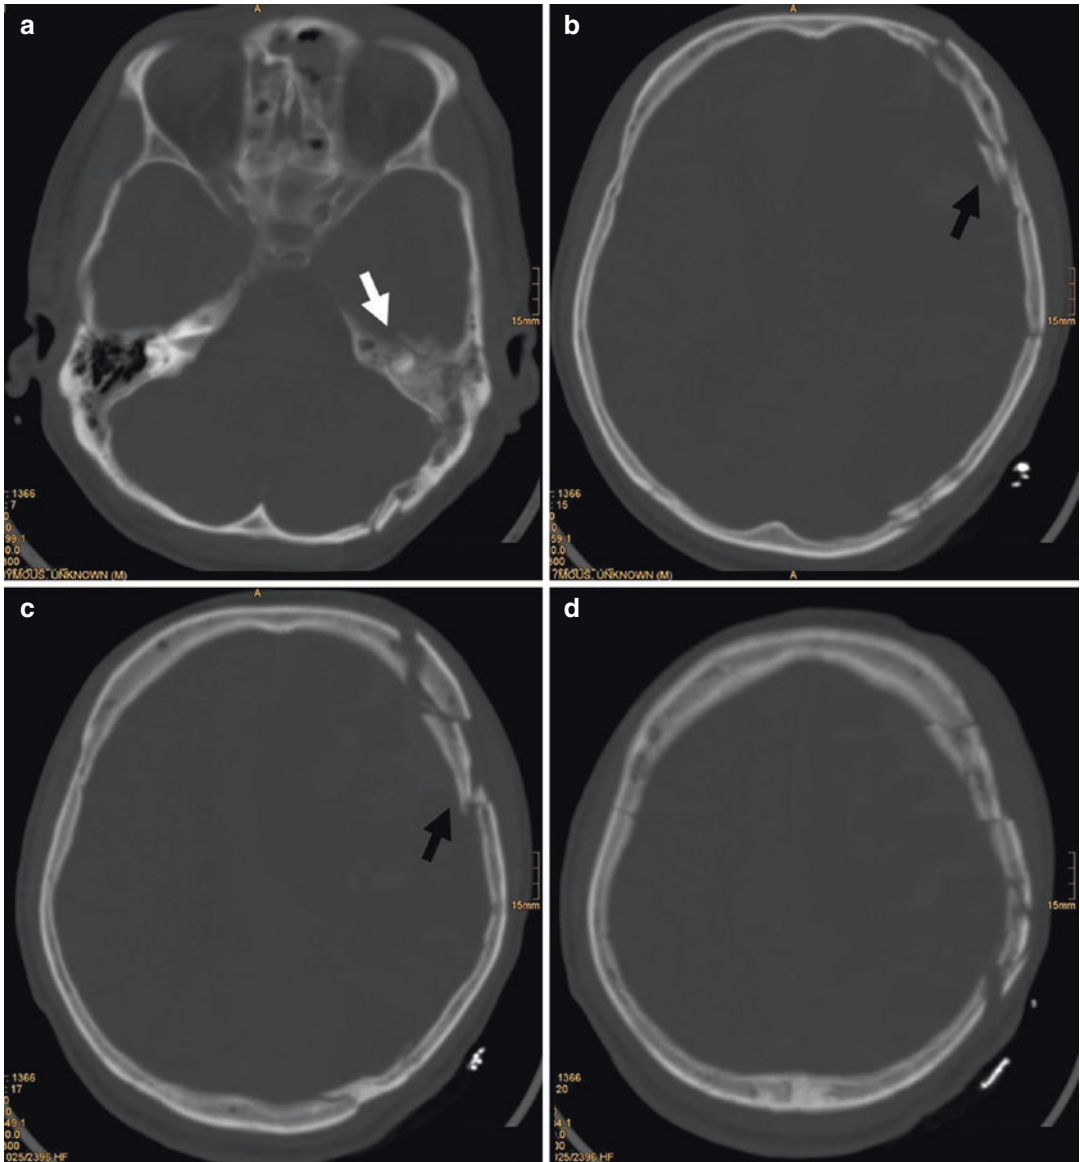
(a–d) CT scan. Presence of comminuted fractures in the left occipital and frontal regions with depressed bone fragments (*black arrows*); a longitudinal left temporal fracture is associated (*white arrow*)
